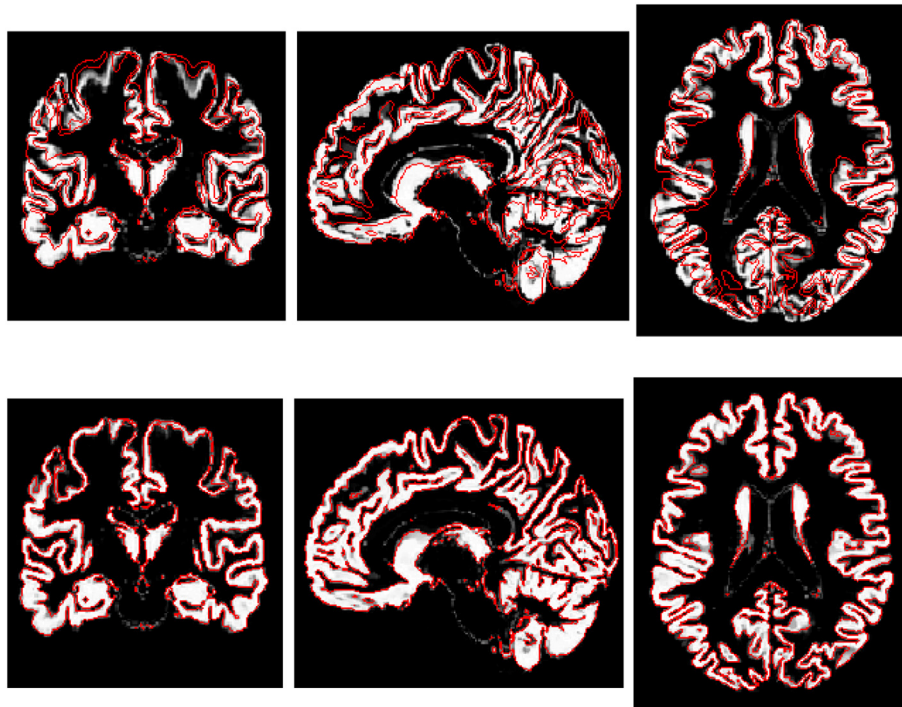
Gray matter segmentation of a representative patient, transformed to the MNI space. Top: CT-based deformation, bottom: MR-based deformation. A contour was drawn on the bottom-row images and applied to the top row, to facilitate comparison.
